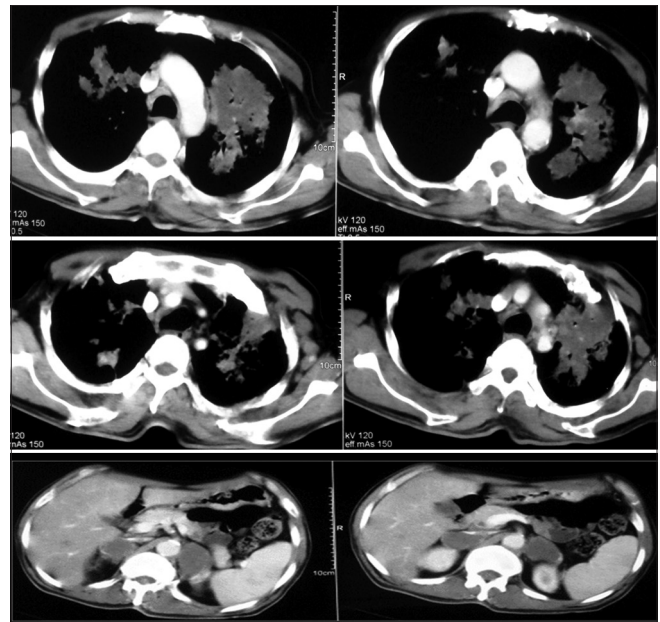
Chest and abdomen computed tomography
